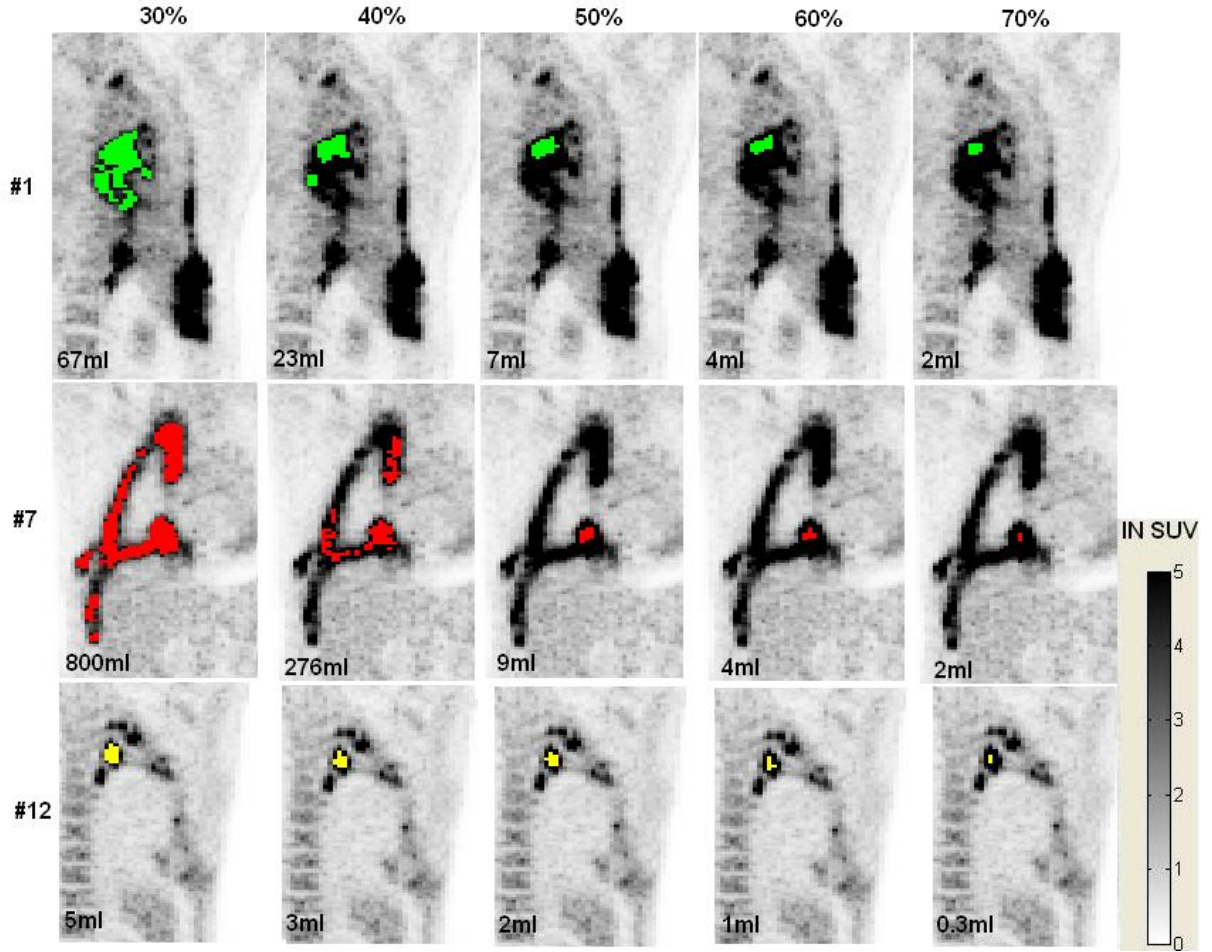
Segmentation using Percentage of SUV_{max}
